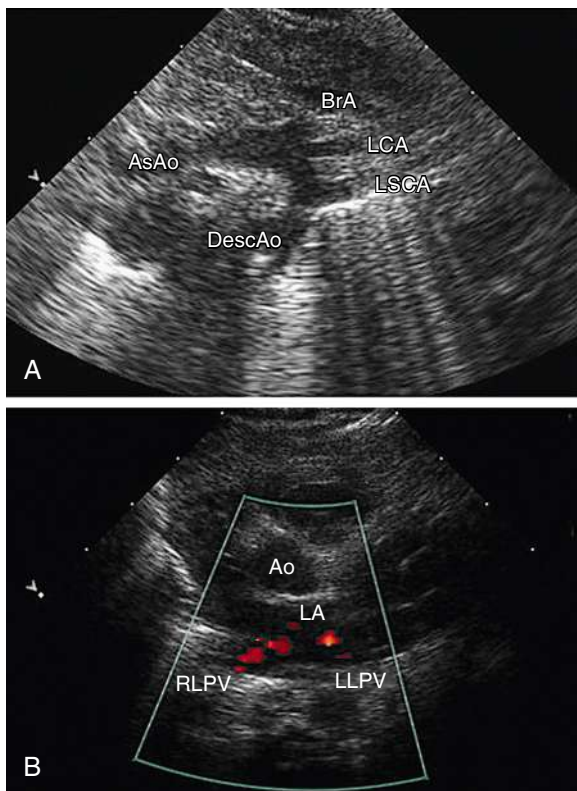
A, Normal suprasternal echocardiographic window showing the aortic arch and its major branches. B, Normal high parasternal window showing color Doppler imaging of normal pulmonary venous return to the left atrium (LA) of both right (RLPV) and left (LLPV) lower pulmonary veins. AsAo, Ascending aorta; BrA, brachiocephalic artery; DescAo, descending aorta; LCA, left carotid artery; LSCA, left subclavian artery.
